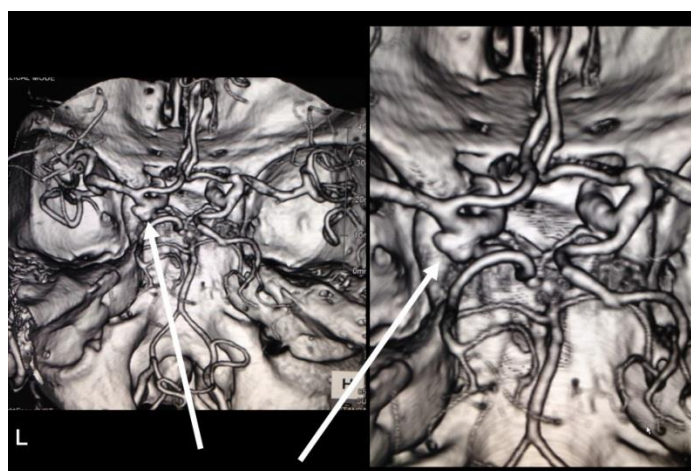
Computed tomographic angiogram on the 2nd day
